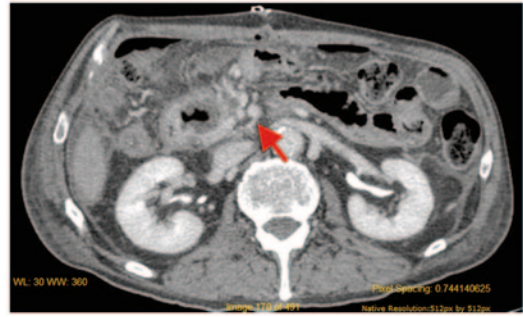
Contrast-enhanced computed tomography (CT) of the abdomen, especially when coupled with thin cuts through the porta hepatis, has a high sensitivity (90%) and specificity (99%), as well as a more accurate delineation of the portal vein anatomy that contains thrombus
